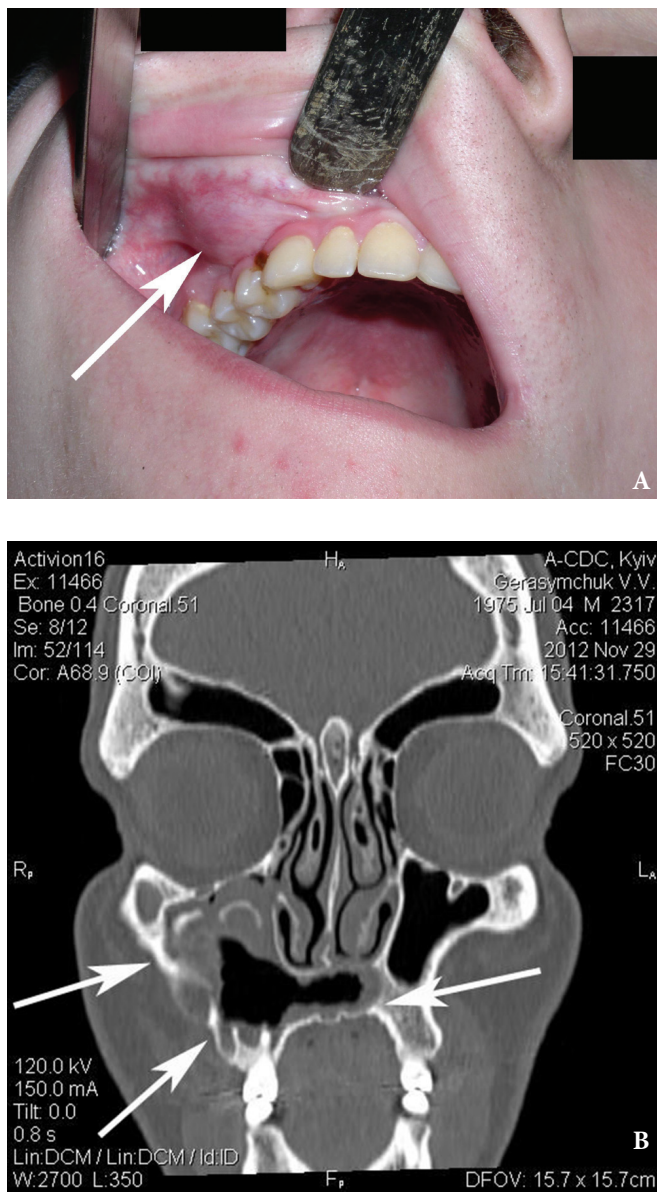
View of a 40-years-old male patient with ameloblastoma (arrow) of the right mandible (A). On coronal CT image (B), the tumor is marked by arrows.
